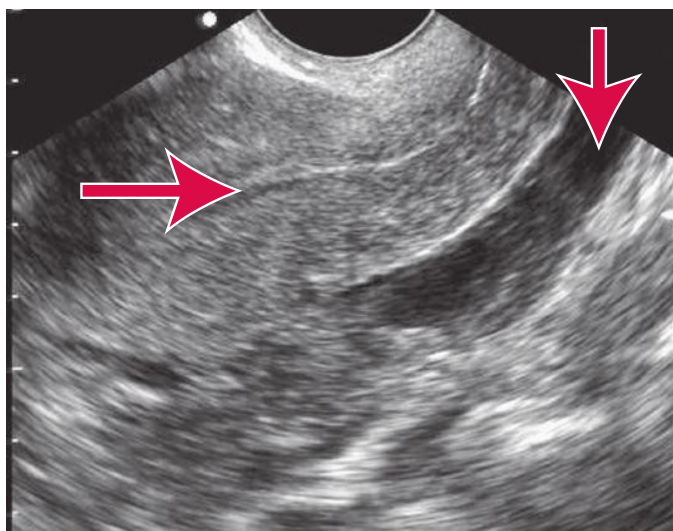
Ectopic pregnancy: empty uterus and free fluid in the posterior cul-de-sac. Transvaginal sagittal image. Horizontal arrow points to empty uterus (uterine stripe), and vertical arrow points to fluid in the cul-de-sac. [Reproduced with permission from Ma OJ, Mateer JR, Reardon RF, Joing SA: *Ma & Mateer's Emergency Ultrasound*, 3rd ed. © 2014, McGraw-Hill Inc., New York.]
